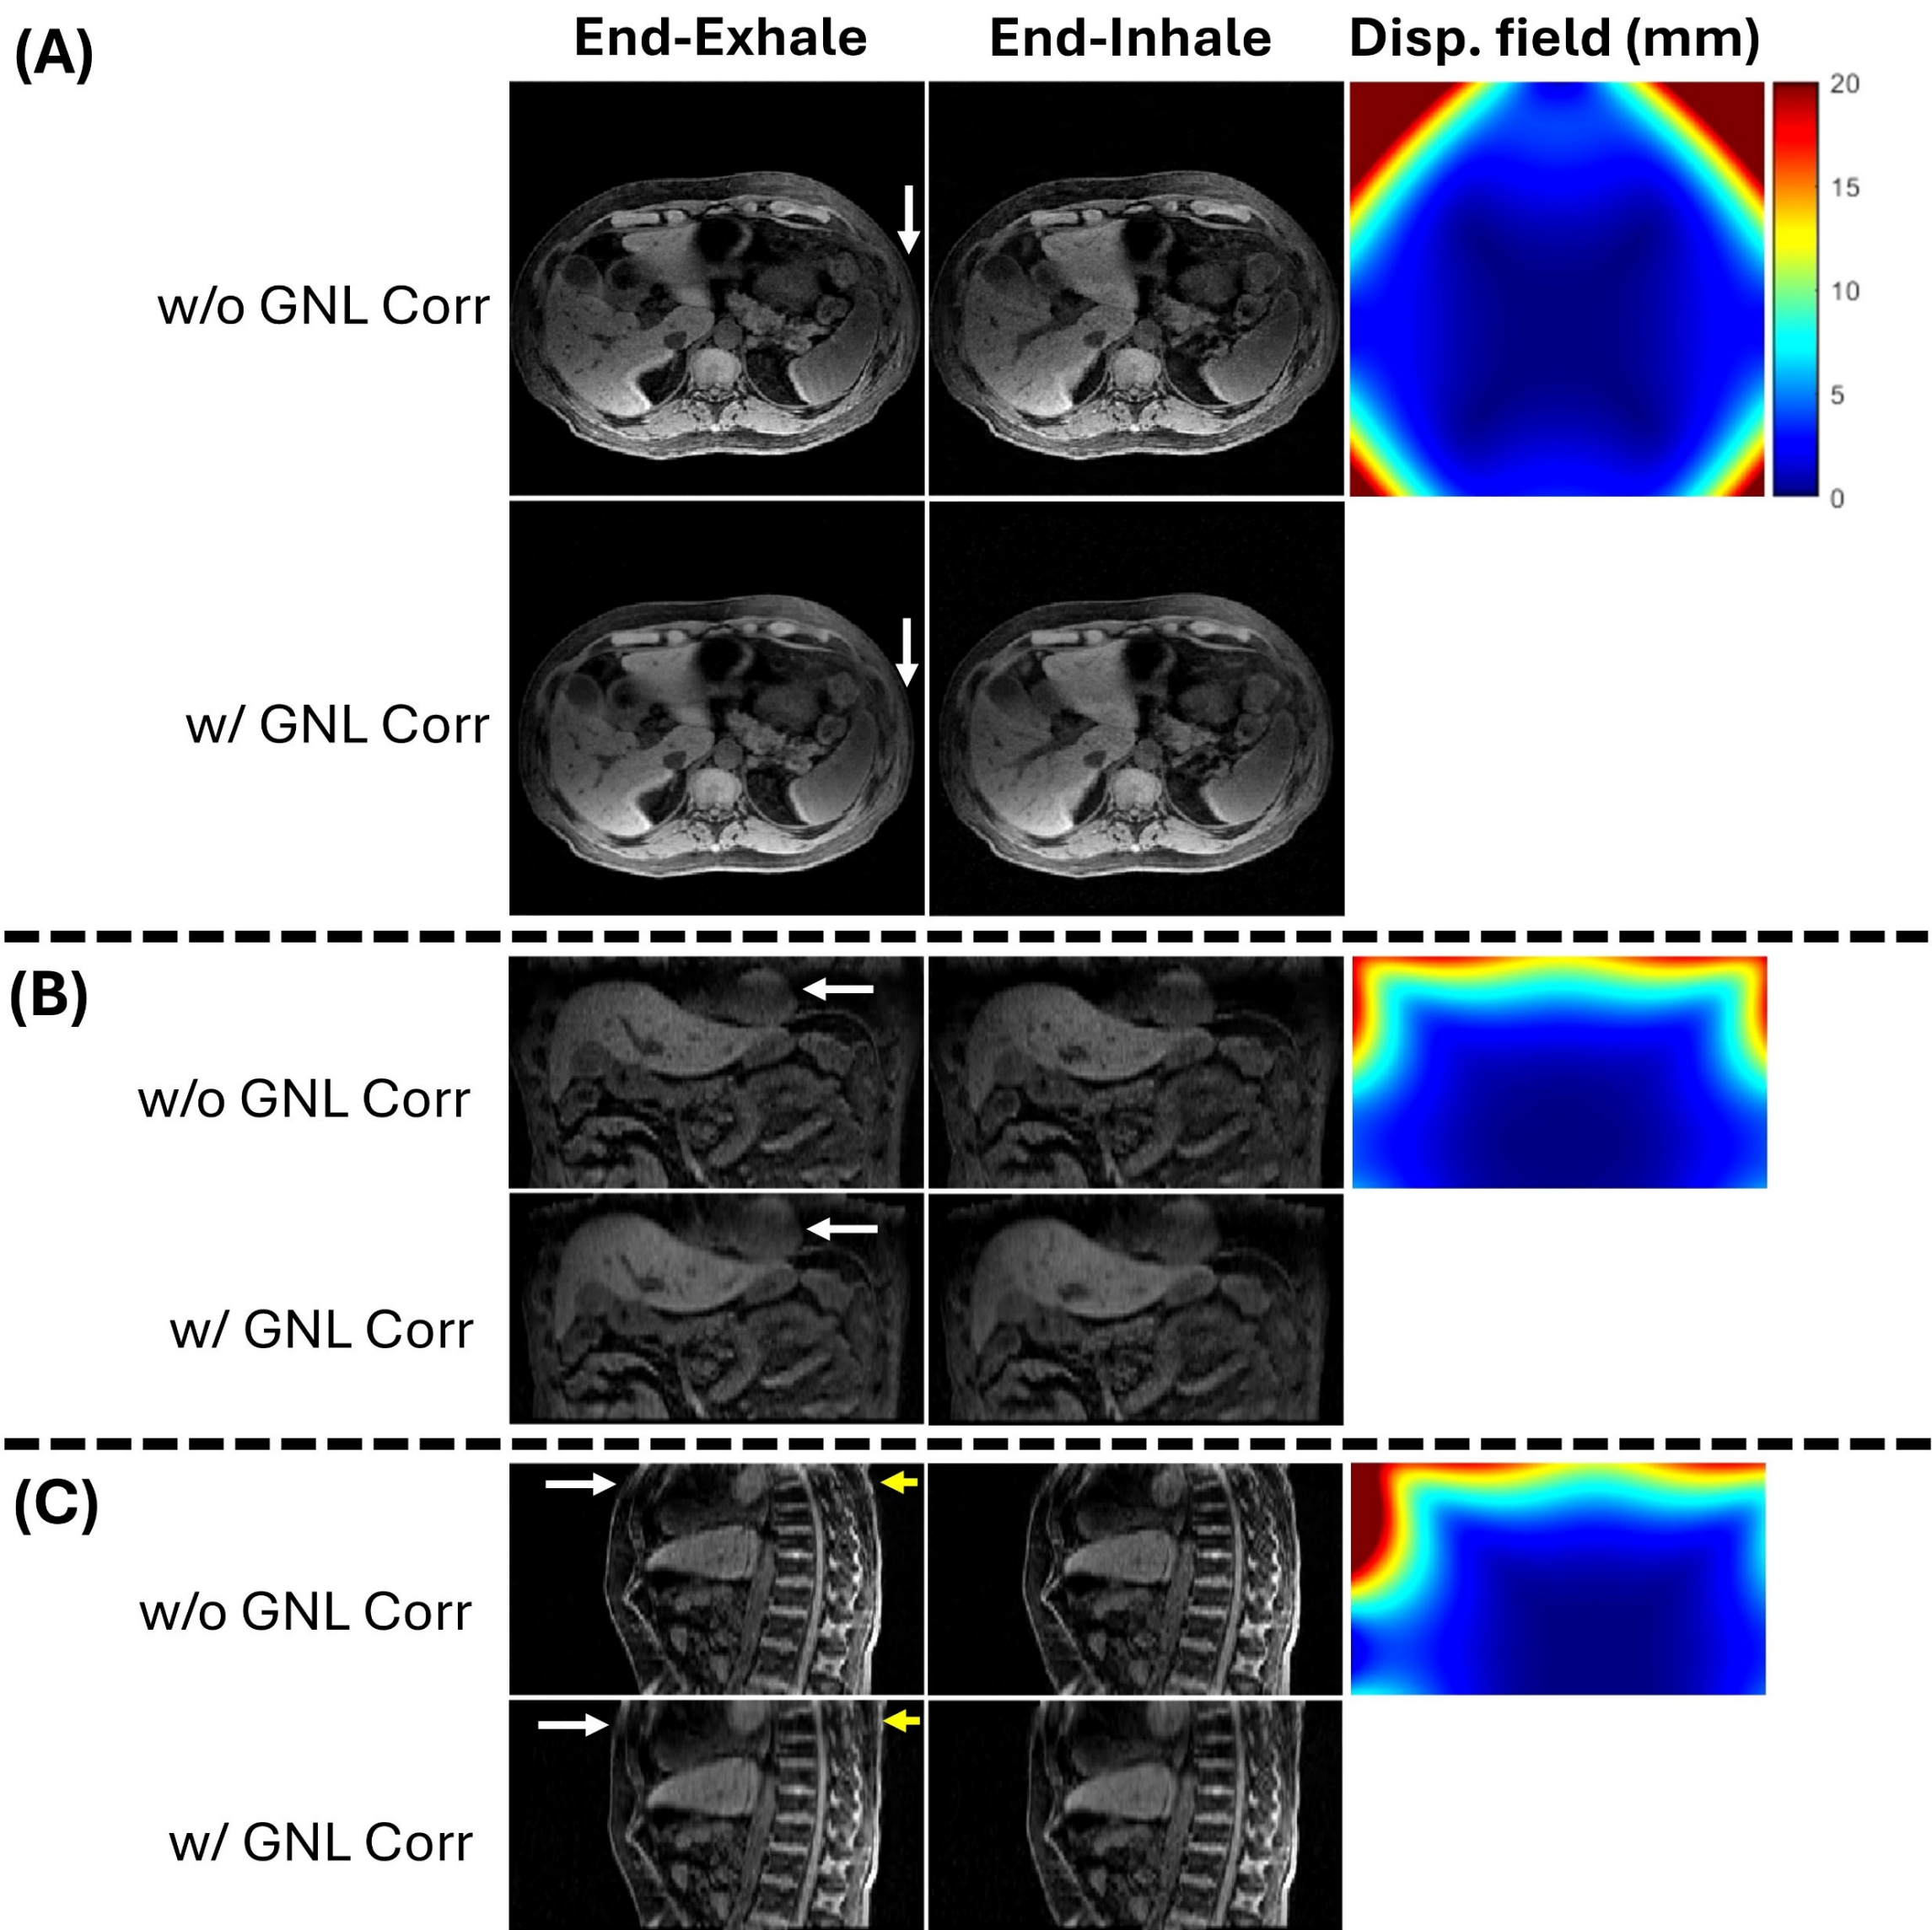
End-exhale and end-inhale respiratory phases in 4D MRI before and after gradient nonlinearity (GNL) correction. GNL correction improves geometric accuracy (arrows), particularly in regions with large displacement fields.
